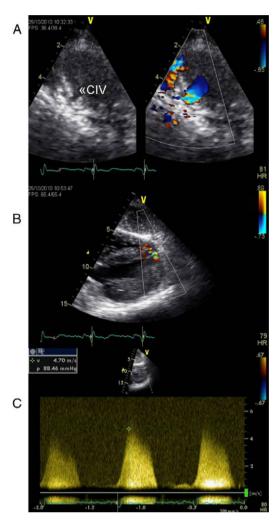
Transthoracic echocardiogram two years after heart transplantation showing two solutions of continuity (A and B) with two high-velocity jets (maximum 5 m/s) (C) from the left to the right ventricle, located in the apical and mid segments of the interventricular septum, that appear to be two restrictive interventricular communications. CIV: interventricular communication.
